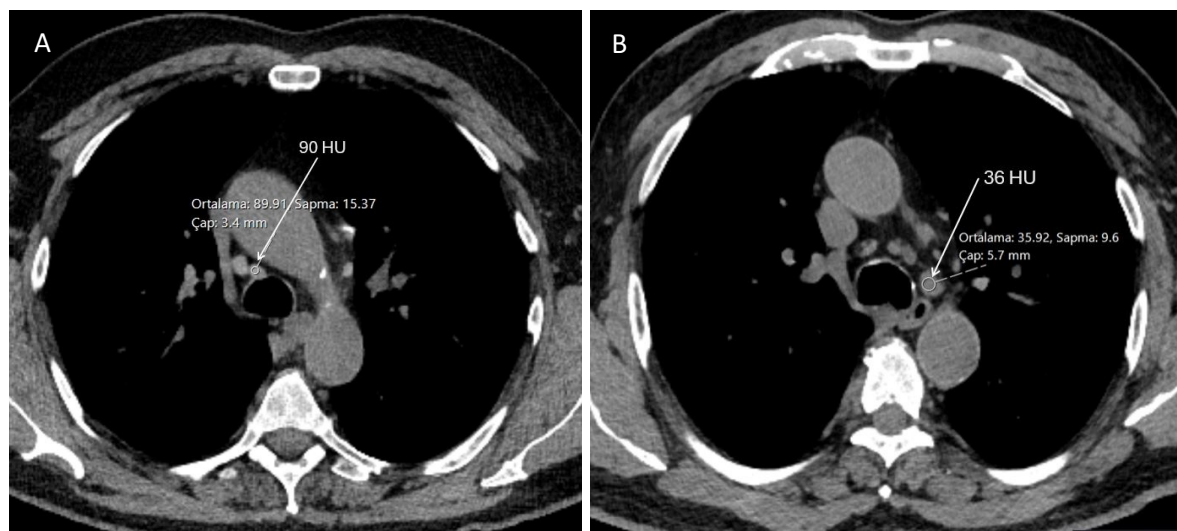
Representative examples of mediastinal lymph node attenuation (MLNA) measurements on non-contrast chest CT. Circular regions of interest (ROIs) were positioned within the solid portion of the lymph node while avoiding calcification, fatty hilum, and adjacent structures. (A) Example from a 67-year-old active smoker with diabetes mellitus demonstrating increased attenuation in the 4R lymph node station (90 HU). (B) Example from a never-smoker demonstrating lower attenuation in the 4L lymph node station (36 HU).
